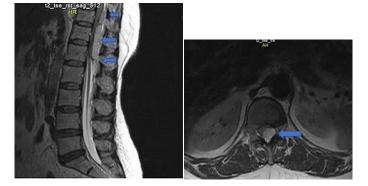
a) Preoperative T2 MRI sagittal section of the thoracolumbar spine shows hyperintense T11-L1 SSEH and cord compression (blue arrows); b) Axial view of SSEH in the thoracolumbar spine in a preoperative T2 MRI section (blue arrow)
